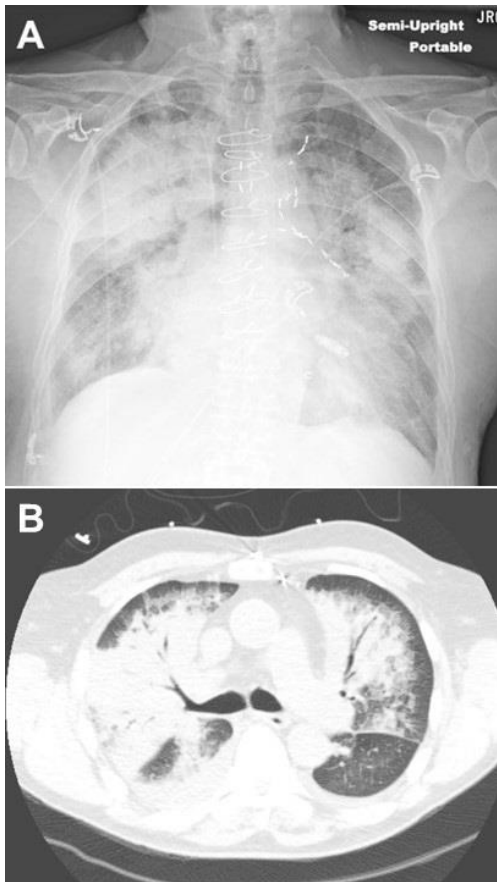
A: Repeat portable chest x-ray and B: CT scan in lung windows done on 10/30.
